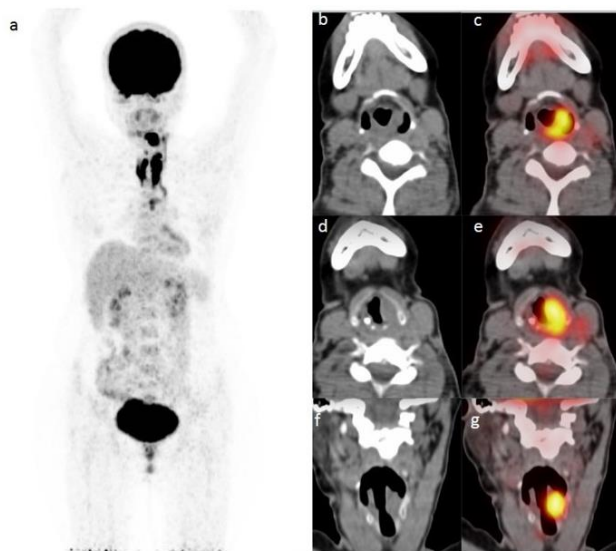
(a) Maximum intensity projection (MIP) image of 18F-fluorodeoxyglucose positron emission tomography computed tomography (18F-FDG PET CT); (b-e) increased FDG uptake in soft tissue nodule in left vocal cord in transaxial view and (f & g) coronal view.
